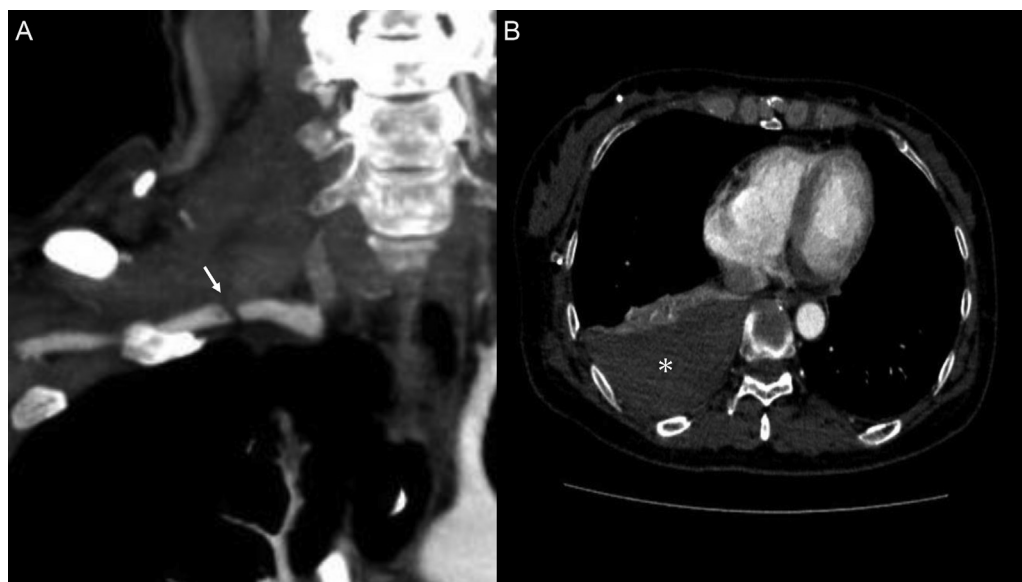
Contrast-enhanced chest computed tomography. (A) A partial irregular stenosis and contrast defect in the right subclavian artery (arrow). The normal portion of the right subclavian artery measured 5 mm in diameter. (B) A right hemothorax without extravasation of contrast agent into the thoracic cavity (*). Peripheral blood flow was preserved from the injured area.
